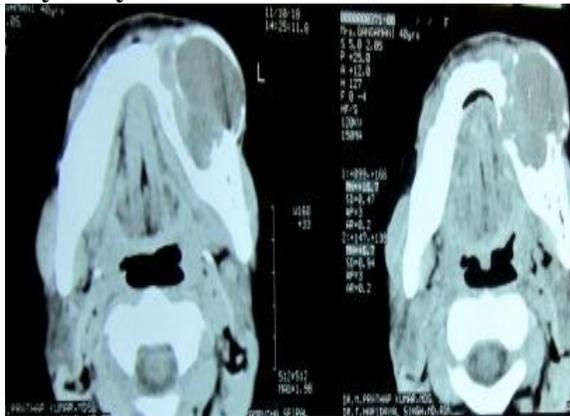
CT scan showing lingual cortical perforation
